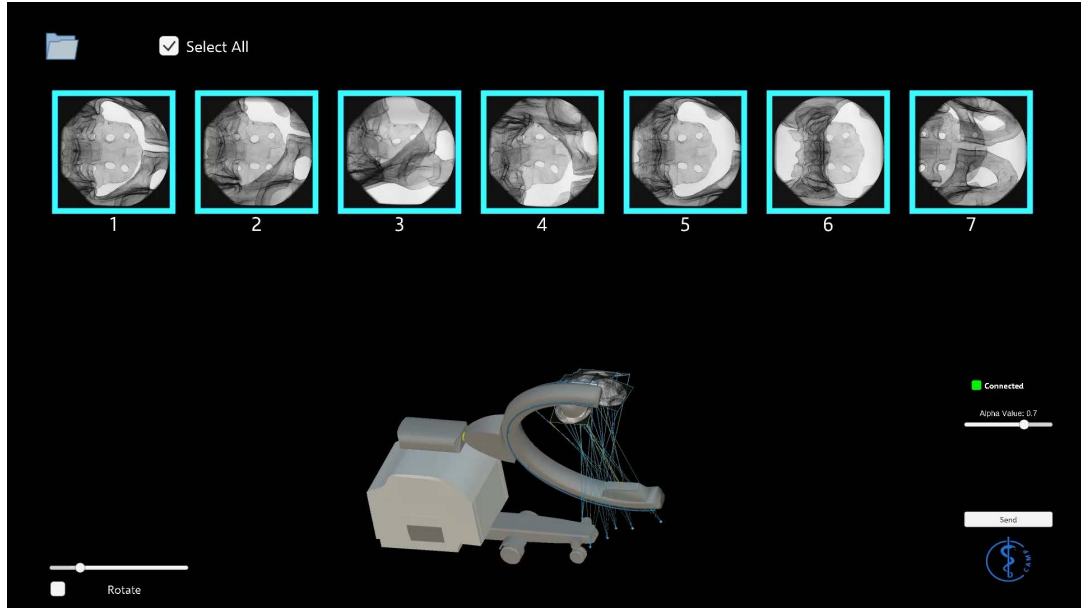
multiple views of IFFs shown on the PC running on Windows 10. The user is able to manipulate IFFs on the C-arm to preview the X-ray images from different angles.
